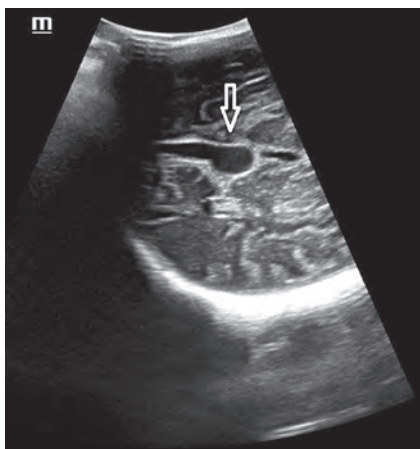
Sagittal view cranial sonography showing Vein of Galen noted as anechoic tubular midline structure (white arrow)
